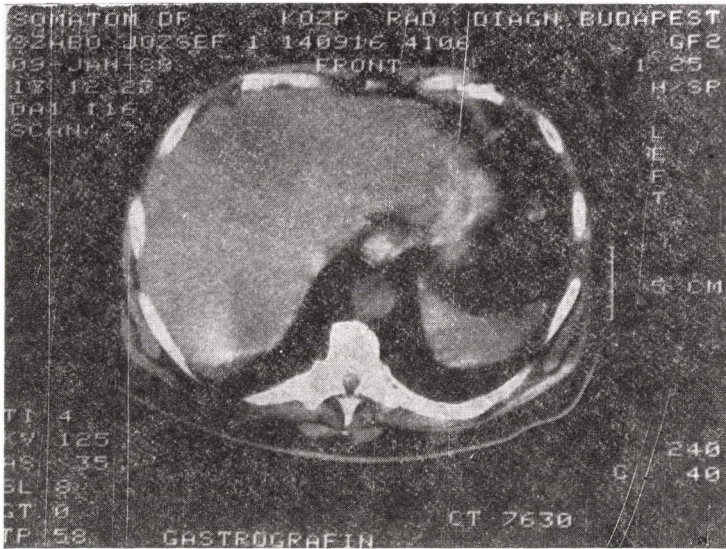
CT (09, 1, 1988). Following administration of contrast medium, in the hepatic lobe a definite echodensity of the marginal region of an inhomogeneous area, 10 cm in diameter, visualized also by X-rays, appears, with several cystose regions of a diameter of 0.5–3 cm showing no uptake of contrast material. The gallbladder is distended, with a thickened wall
